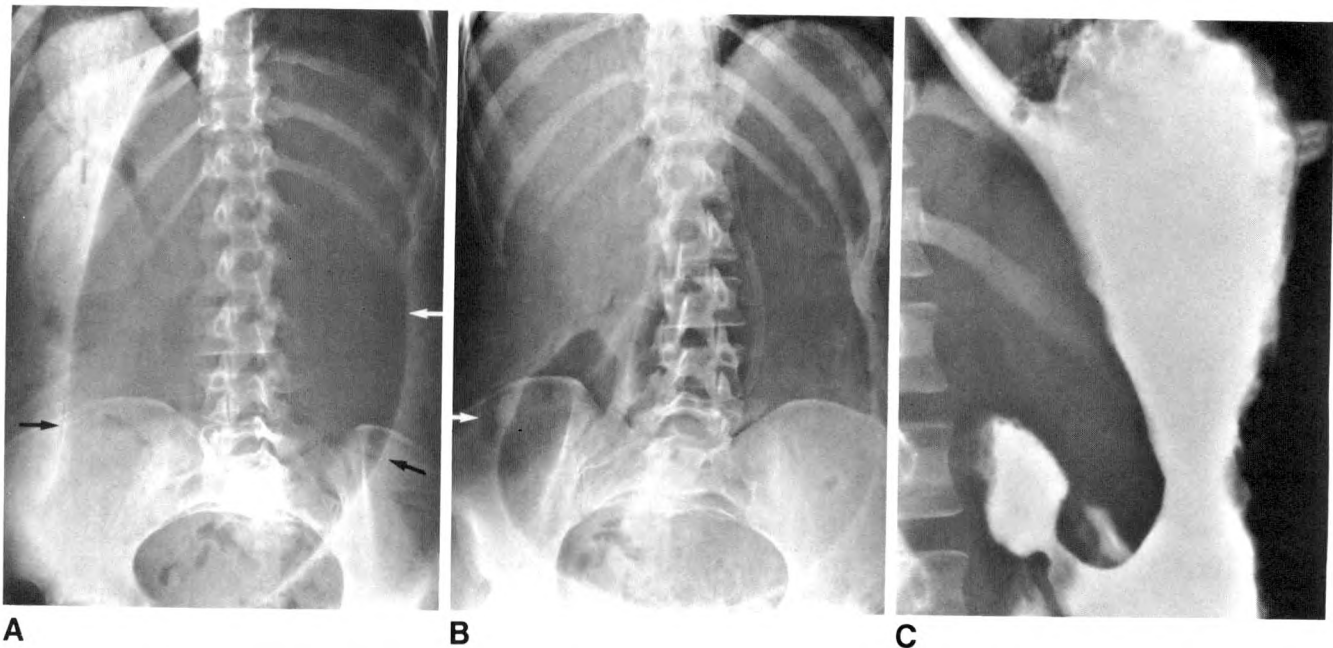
A, Abdominal radiograph. Massive gastric dilatation with lucent streaks in stomach wall (arrows). Branching lucencies in right upper quadrant extend to within 2 cm of liver capsule.
